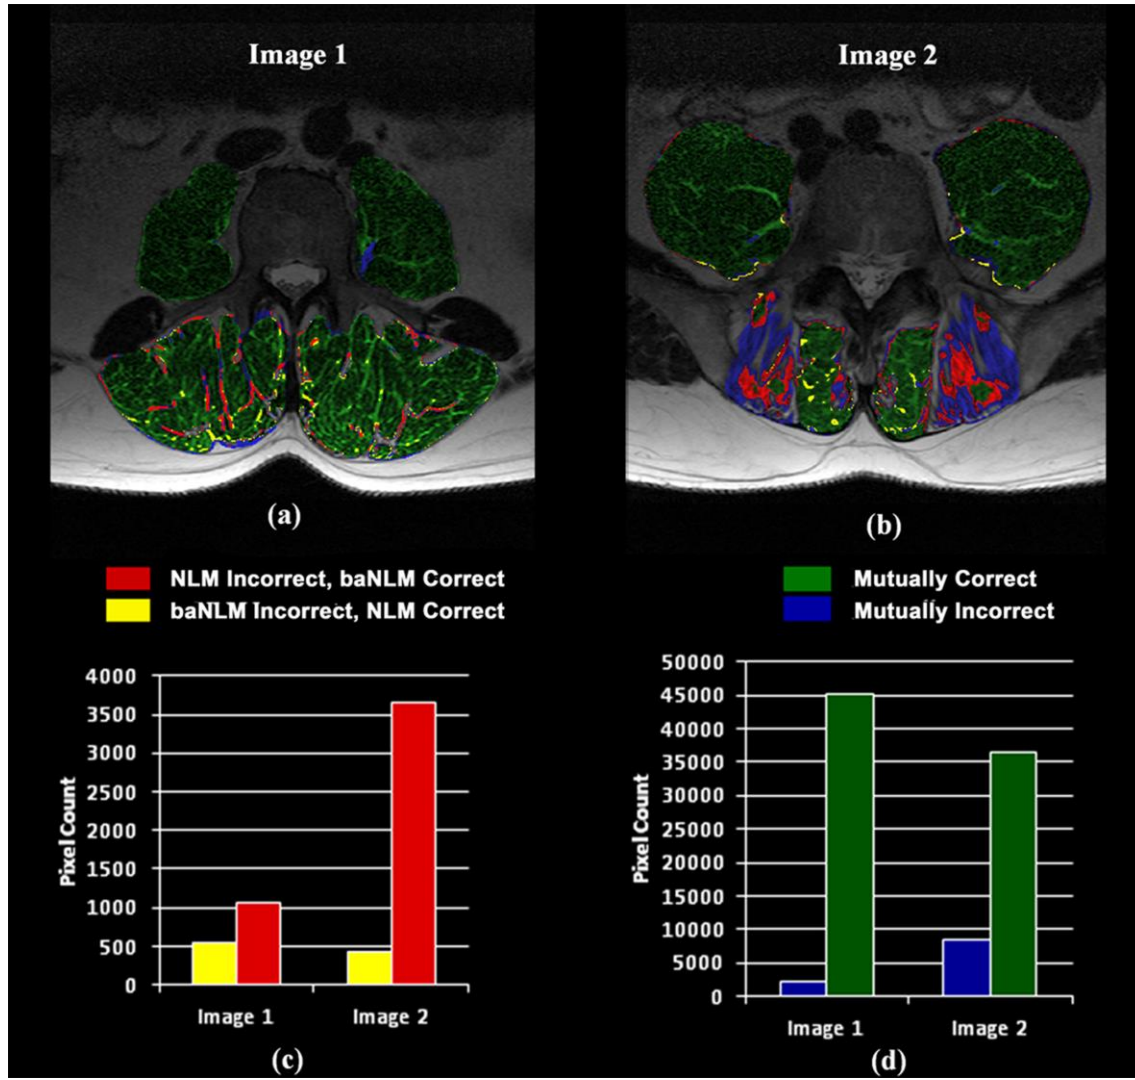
Automatic segmentation accuracy of muscle tissue for two different MR images (a, b). Each image was processed independently with baNLM and NLM, and then classified with fuzzy c-means clustering. The classification results of the images from both filters are overlaid on a single image and color coded based on correspondence of the classification results. Green depicts regions where baNLM and NLM were mutually correct, while blue indicates where they were mutually incorrect (b, d). Red indicates baNLM was correct and NLM was incorrect; while yellow indicates NLM was correct and baNLM was incorrect (a, c). Incorrectly classified pixels were identified as both false-positives and false-negatives, while correctly identified pixels were associated with only true-positive muscle tissue. The classifications from both images show baNLM (yellow) had significantly less mutually exclusive misclassifications than NLM (red) in both images (c).
